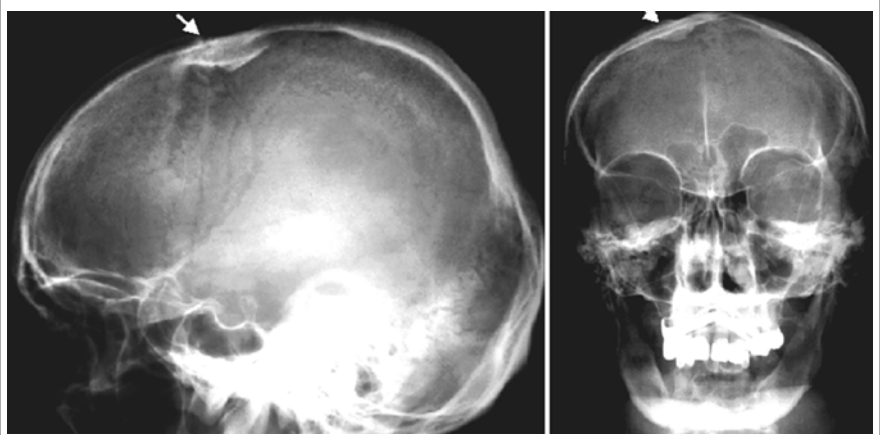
SKULL RADIOGRAPH
